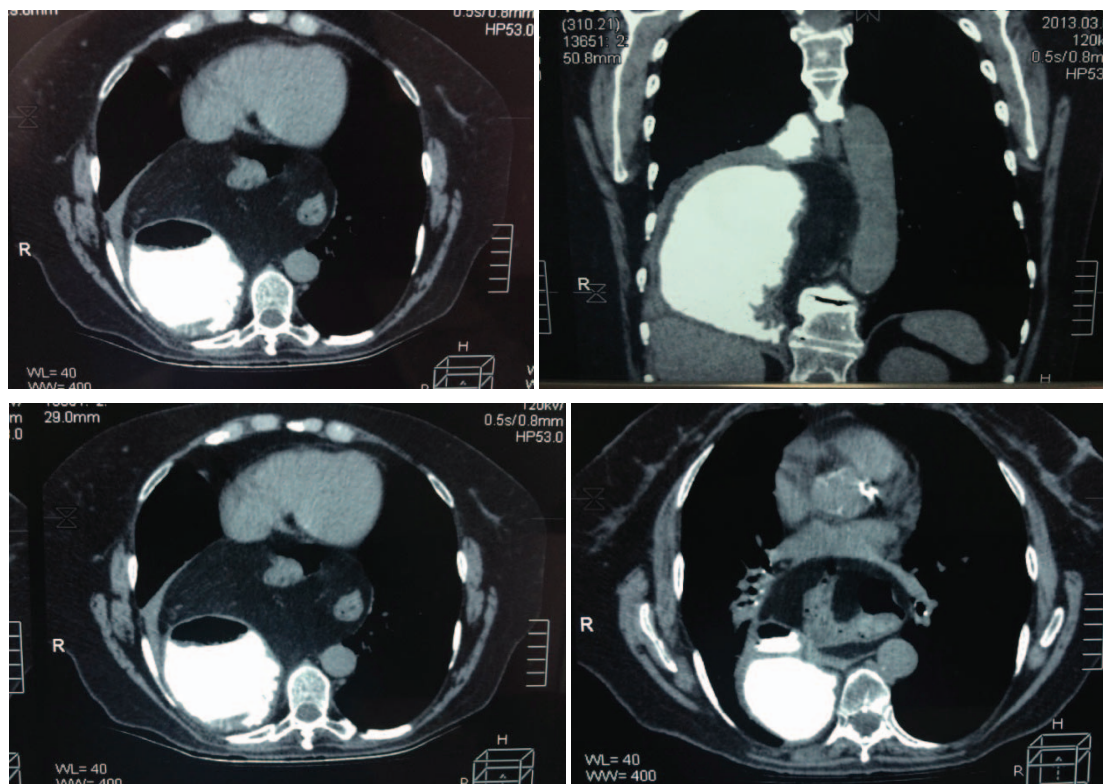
Computed tomography (CT) findings are dominated by the large rear right diaphragmatic hernia with the hernia sac that reaches the carina trachea and urges the principal bronchi. The stomach, duodenum and proximal part of jejunal winds, as well as greater amount of omental and mesenteric adipose tissue are localized in hernial sac.
